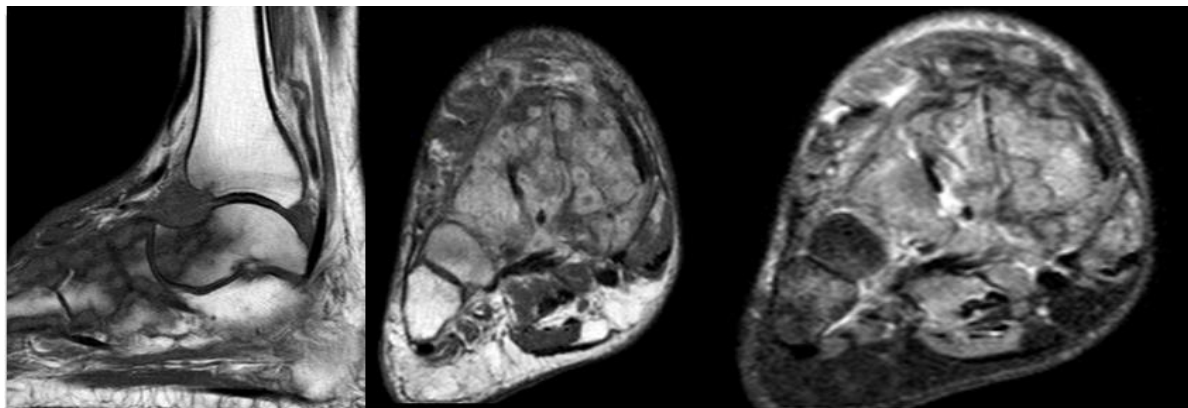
Mycetoma, A 50year old Female patient presented with foot swelling and multiple sinus discharge and treated for chronic OM and bone TB with no improvement. Sagittal T1, Coronal Post contrast T1 and SPAIR MRI images showed multiple different sized nodules in the soft tissue and tarsal bones which has T1 intermediate signal intensity and showing peripheral enhancing rim with central non enhancing dot. They are Hyper intense on SPAIR with central hypo intense dot and soft tissue and bone marrow edema.
